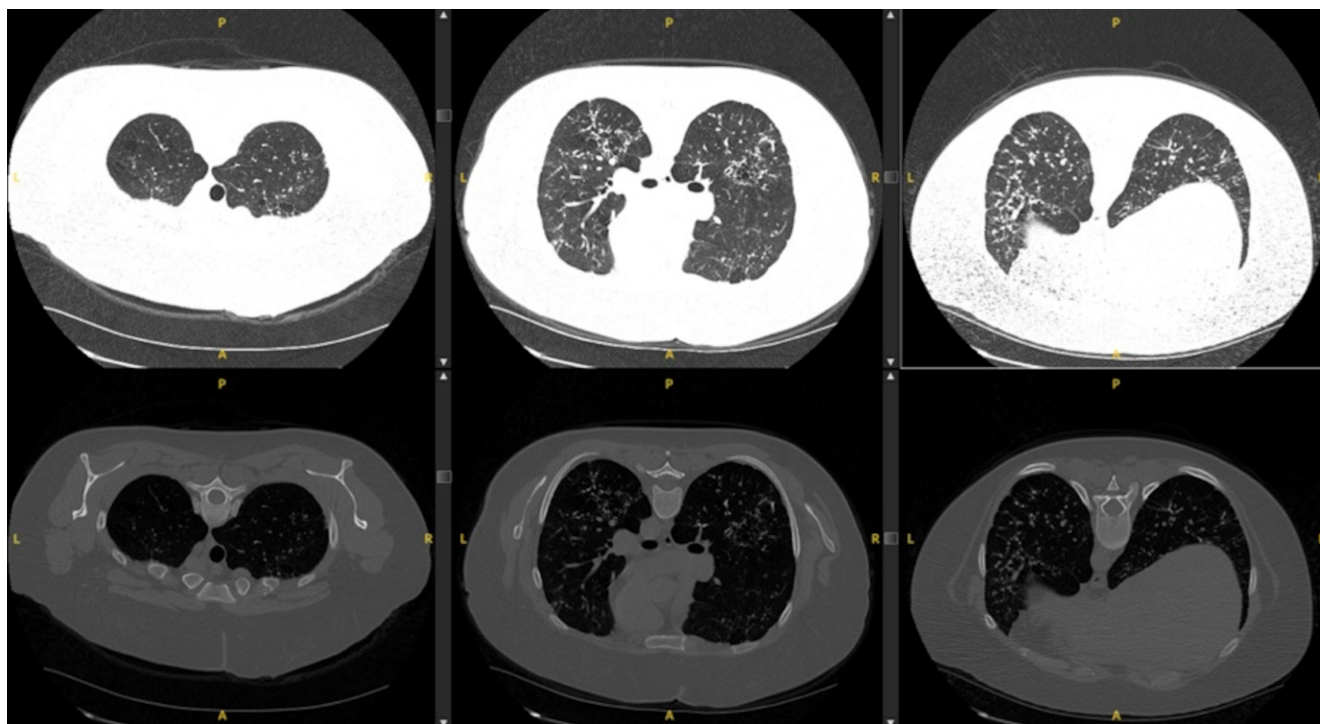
Upper row: Axial high-resolution CT thorax images as viewed in the lung window setting, showing calcified interlobular septa with widespread bilateral intra-alveolar deposition of sand-like calcifications throughout the lungs, predominantly in the lung bases. There is evidence of a cluster of small subpleural cysts in the right upper lobe. Lower row: Axial high-resolution CT thorax images as viewed in the bone window setting, showing fine, diffuse, basilar-predominant micronodular opacities and subpleural linear calcifications. L, left; R, right; A, anterior; P, posterior.
